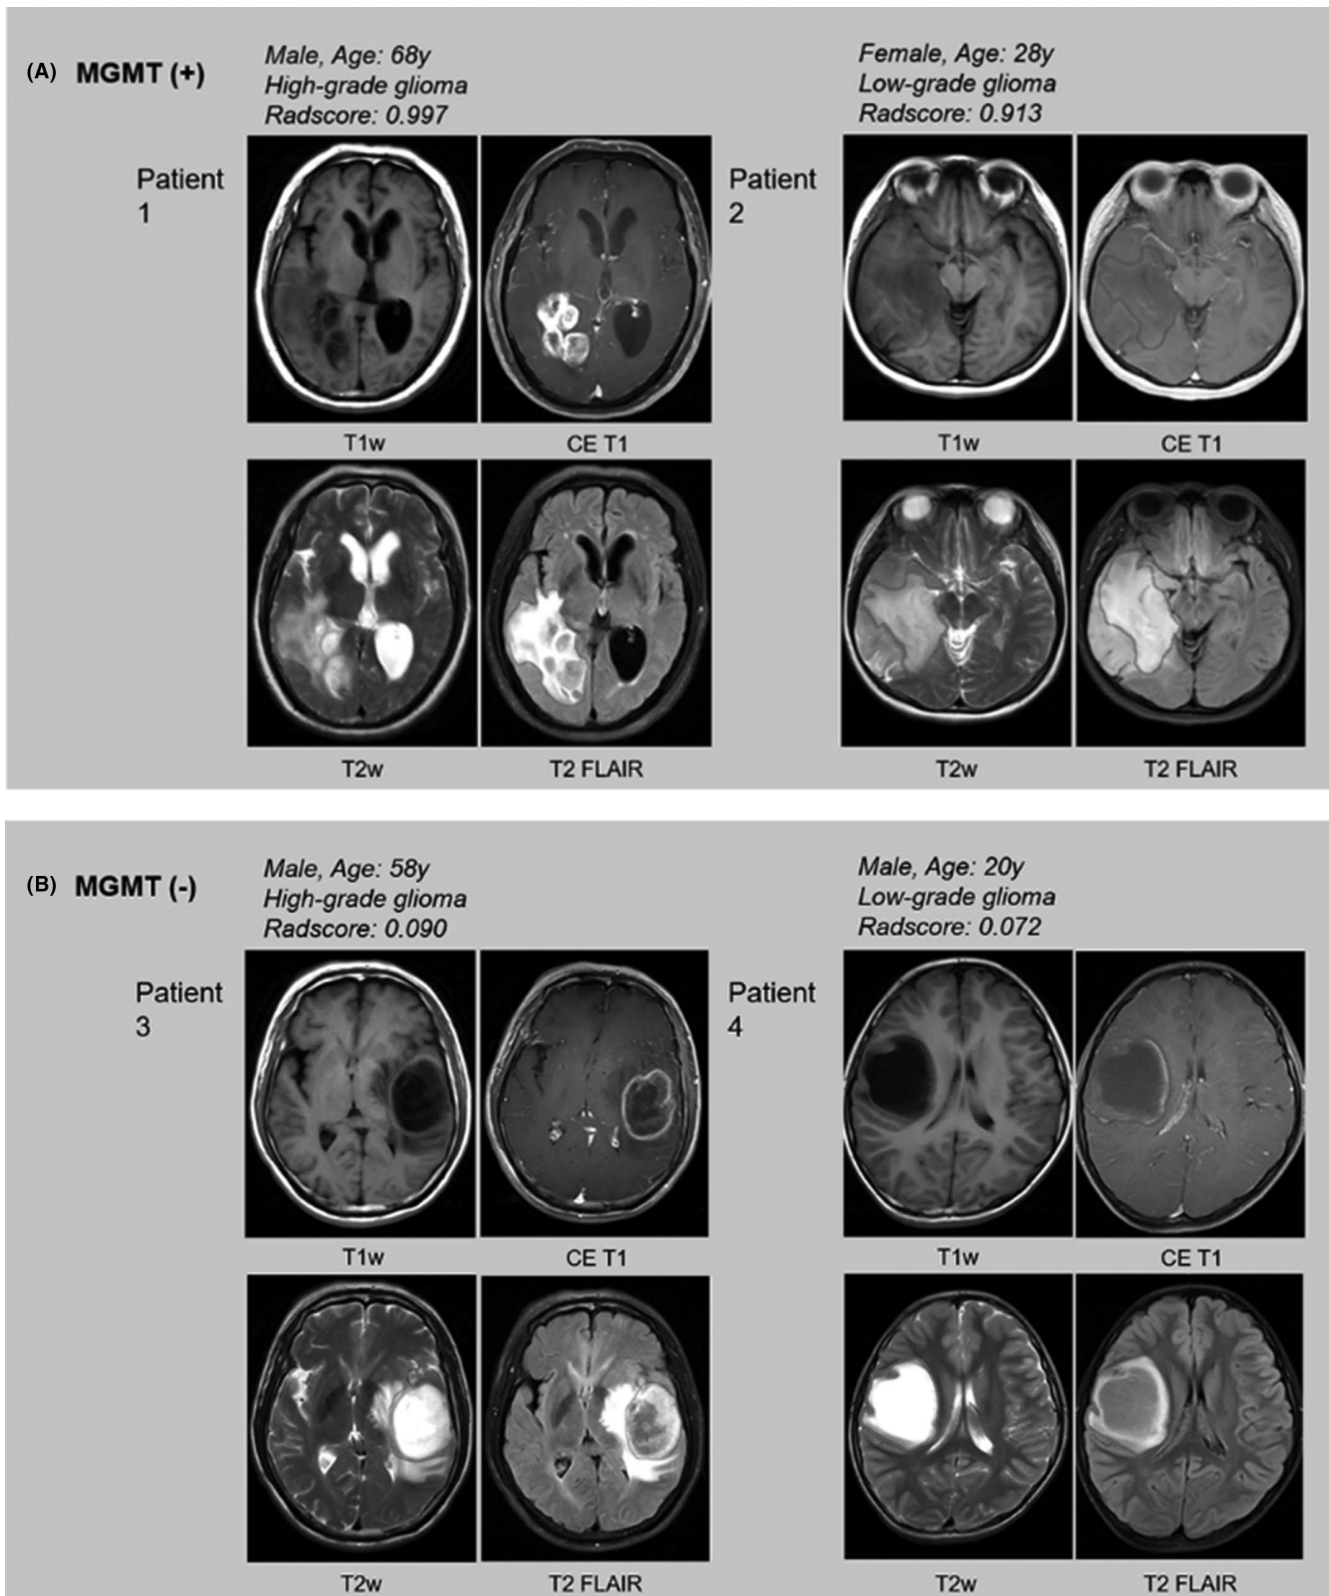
Representative images of glioma patients with or without methylguanine methyltransferase (MGMT) methylation. A, Patient 1, a 68-y-old man with MGMT promoter methylated high-grade glioma. The combined model radiomic signature (Rad-score) is 0.997. Patient 2, a 28-y-old woman with MGMT promoter methylated low-grade glioma. The combined model Rad-score is 0.913. B, Patient 3, a 58-y-old man with MGMT promoter unmethylated high-grade glioma. The combined model Rad-score is 0.090. Patient 4, a 20-y-old man with MGMT promoter unmethylated low-grade glioma. The combined model Rad-score is 0.072. CE, contrast-enhanced; FLAIR, fluid attenuated inversion recovery; T1w, T1 weighted; T2w, T2 weighted
